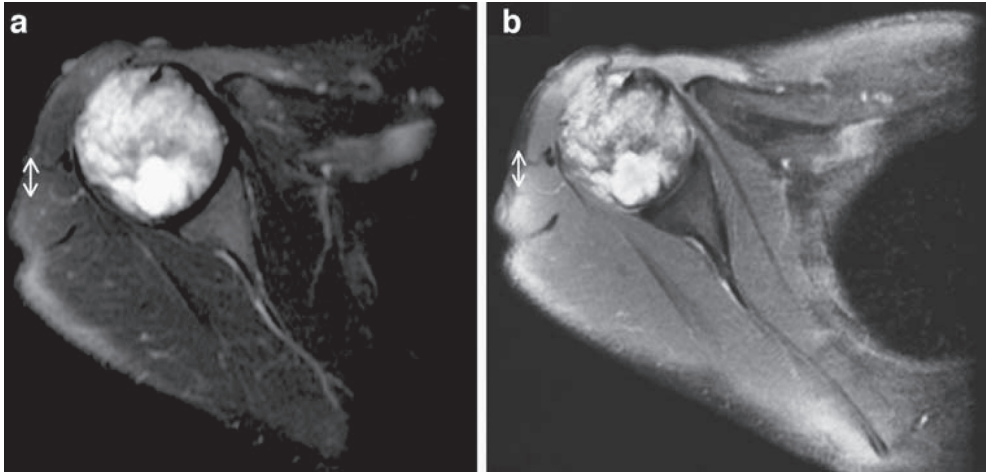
A 29-year-old male patient with non-Hodgkin's lymphoma of the proximal humerus. Axial T1-weighted contrast-enhanced (TR/TE 550/12 ms) (a) and T2-weighted (b) turbo-spin echo (TSE) (TR/TE 3,021/80 ms) images with fat-selective pre-saturation. Intra-osseous tumor localization with no extension into soft-tissue and heterogeneous high SI on both sequences.
